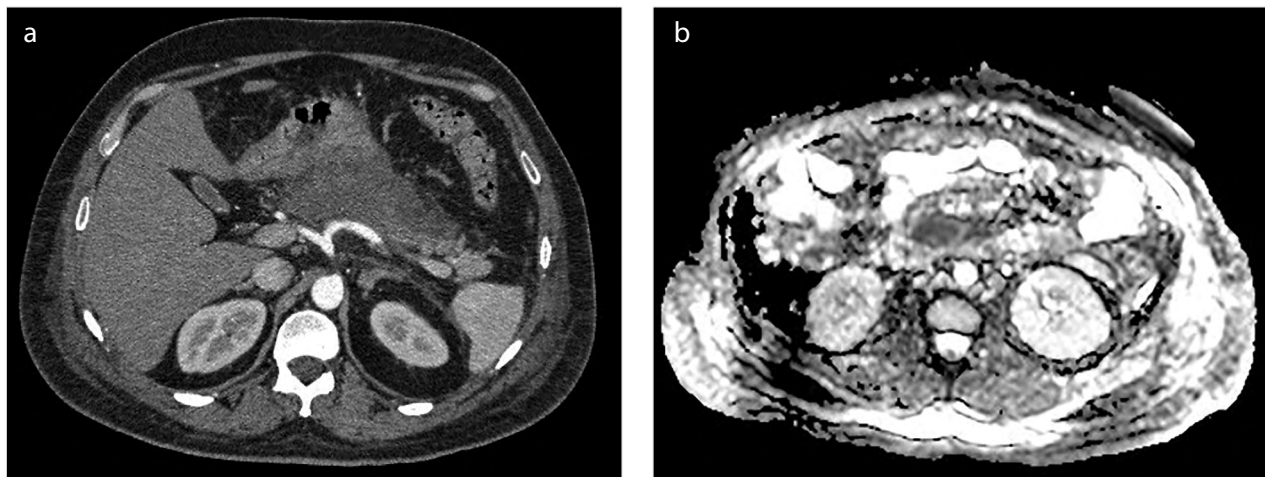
a, b. (a) CT and MRI (b) images of a 48-year-old female patient with acute pancreatitis
